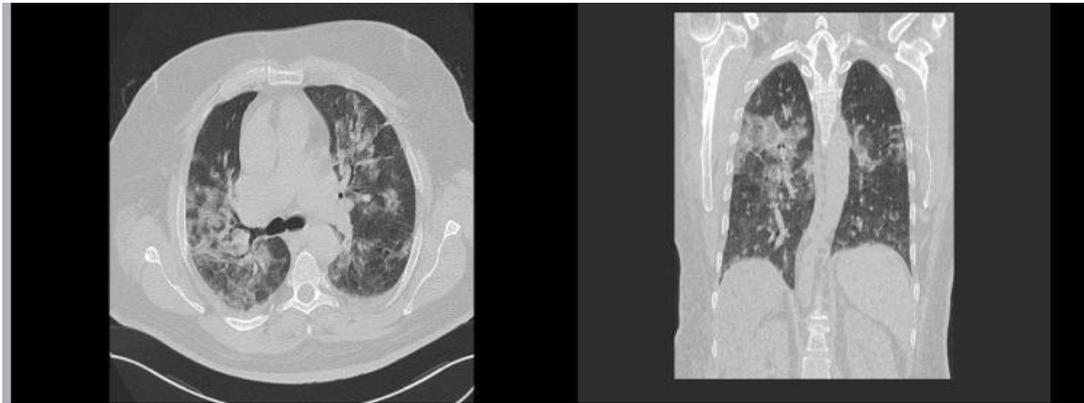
CT Chest observations in both AX and COR sections at admission time
